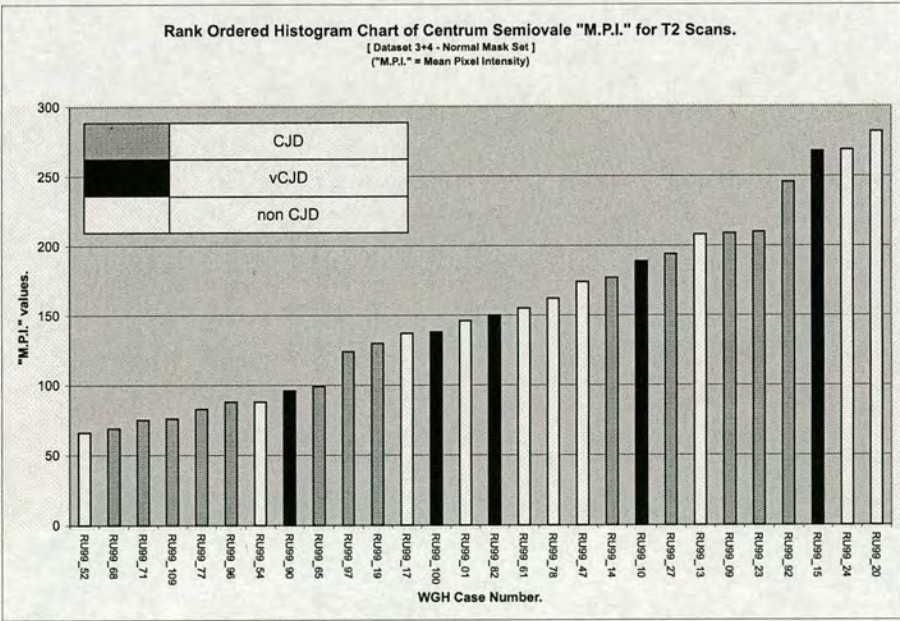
White Matter Changes Tests: Rank ordered histogram of Centrum Semiovale "M.P.I." for the T2 weighted MRI scan-data.
